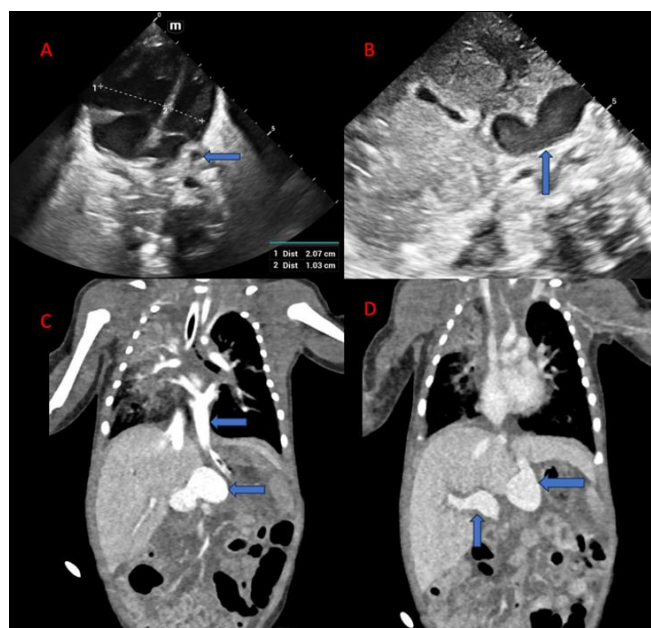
1A: Transthoracic echocardiography in the apical four-chamber view showing dilation of the right heart chambers and a pulmonary venous confluence posterior to the left atrium.
